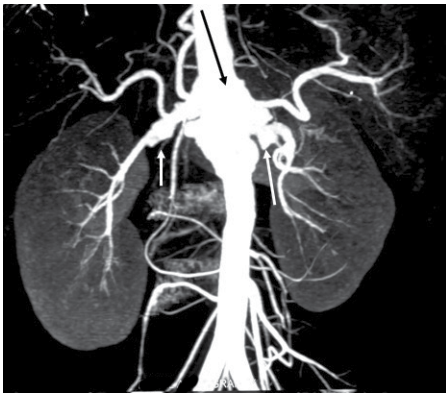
Contrast-enhanced computed tomography of the abdominal vessels shows dilatation of the abdominal aorta near the origin of the proximal superior mesenteric artery (black arrow) and small saccular aneurysms at the proximal parts of the bilateral renal arteries (white arrow)
